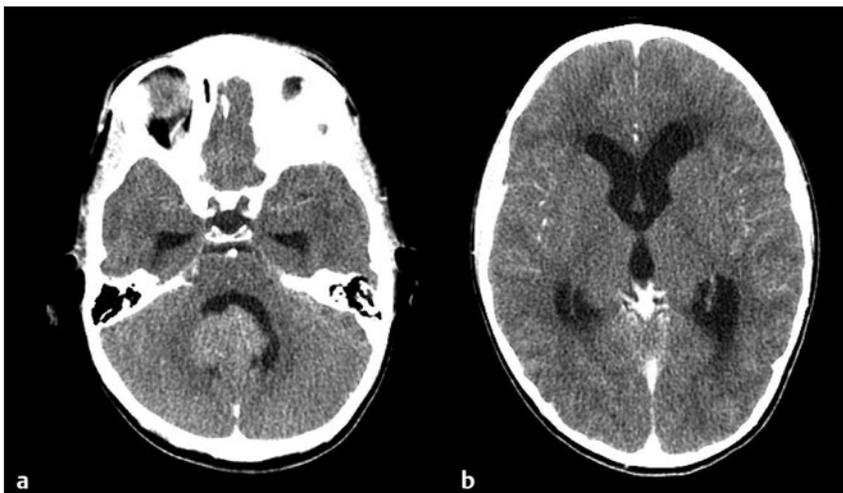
Contrast-enhanced computed tomographic scan through the (a) posterior fossa and (b) third ventricle. Note the significant triventricular hydrocephalus at diagnosis.
